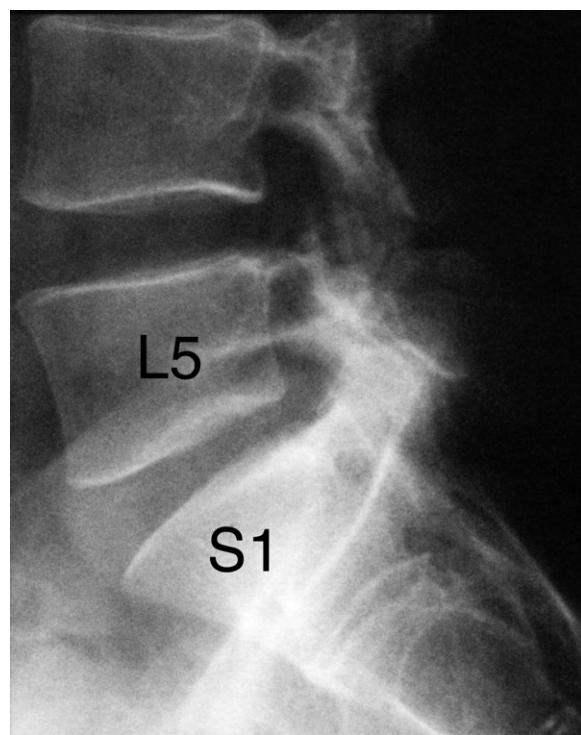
Lumbosacral spine lateral plain X-ray image. Note that the L5–S1 intervertebral disc height is narrower than is the L4–5 intervertebral disc height.
